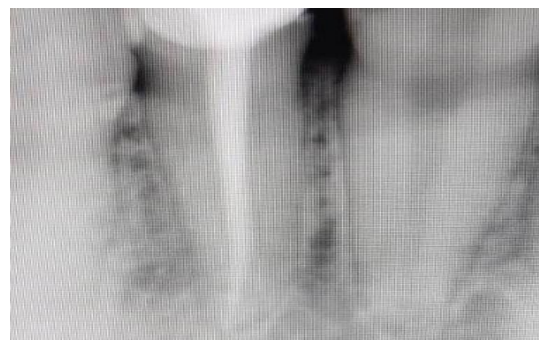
Control radiograph showing the quality of the root canal filling on an incisor with acute irreversible pulpitis
